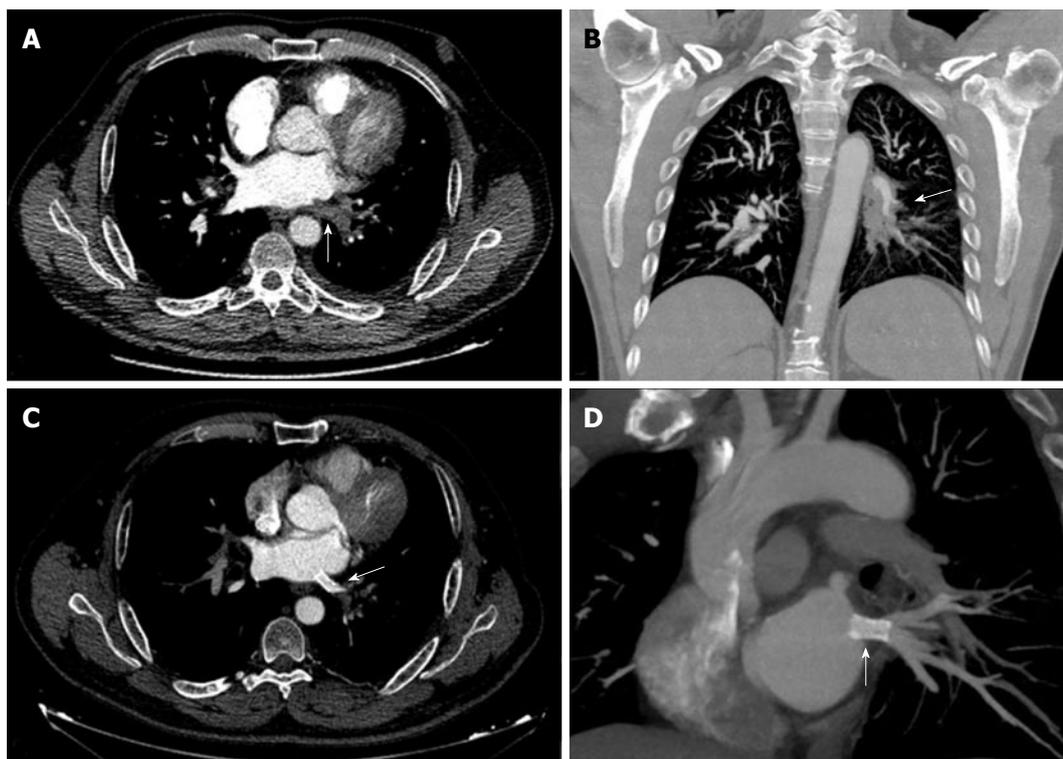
Computed tomography of a patient undergone radiofrequency ablation two months before and recent onset of dyspnea on exertion. A: Absent of contrast (arrow) in the left lower pulmonary vein (complete occlusion); B: Extensive infiltrate within the left lung (arrow) cause by localized edema; C and D: After stent implantation (arrows) flow was successfully restored.
